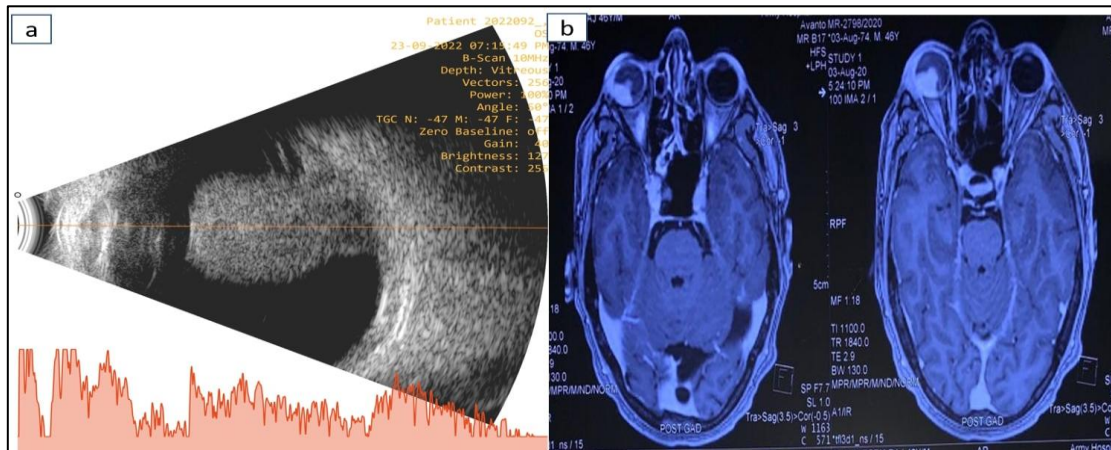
(a and b): Ultrasound B scan of hyperechoic mushroom-shaped intraocular mass. MRI orbit showing intraocular lesion in posterior part of eyeball with no involvement of optic nerve and no sign of extraocular extension.
